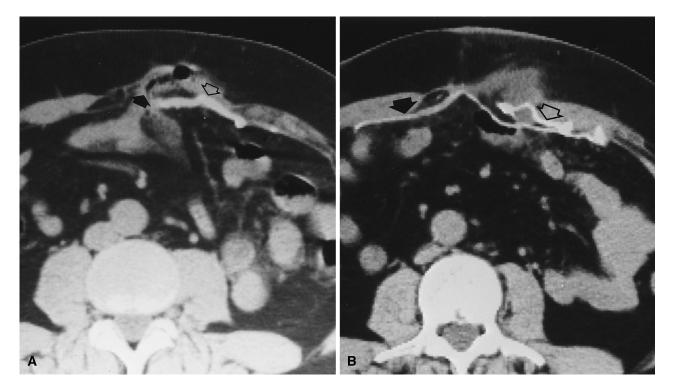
Recurrence after laparoscopic repair of the postsurgical ventral hernia. A CT shows the recurrence of the hernia (*solid arrow*) and the transported mesh (*open arrow*). B After laparoscopic repair, CT shows the wider second mesh (*solid arrow*) and the initial wrinkled and transported mesh (*open arrow*). Fluid in the hernia sac is visible.
